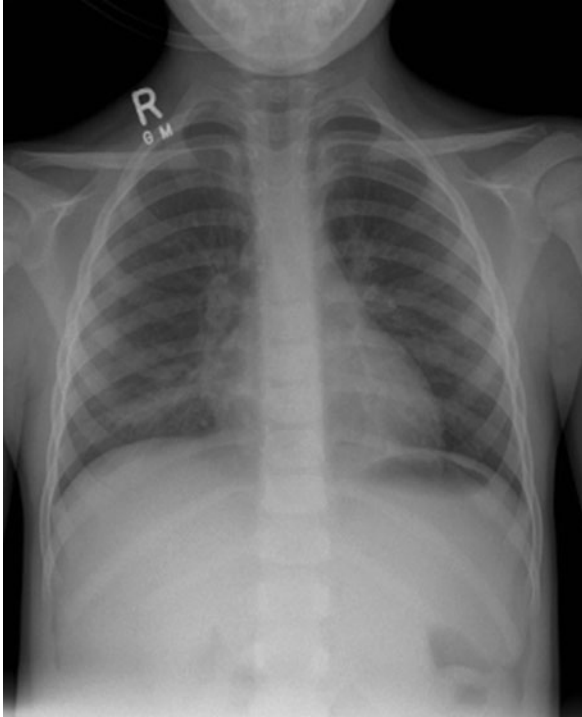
Example of representative radiography showing features of RSV infection
